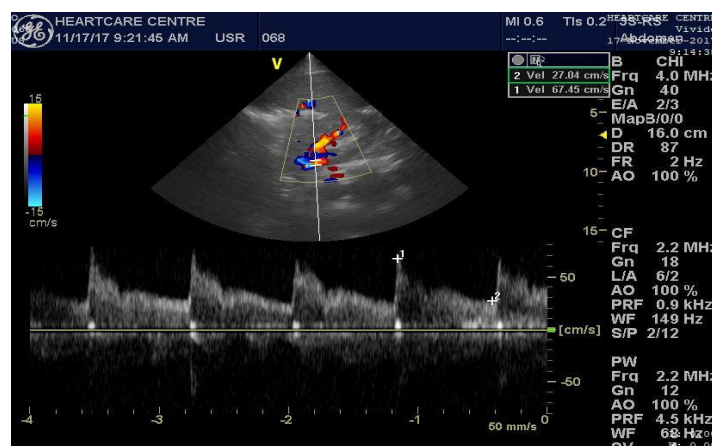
Duplex image spectral doppler waveform of the right main renal artery showing normal resistivity index of 0.60.
